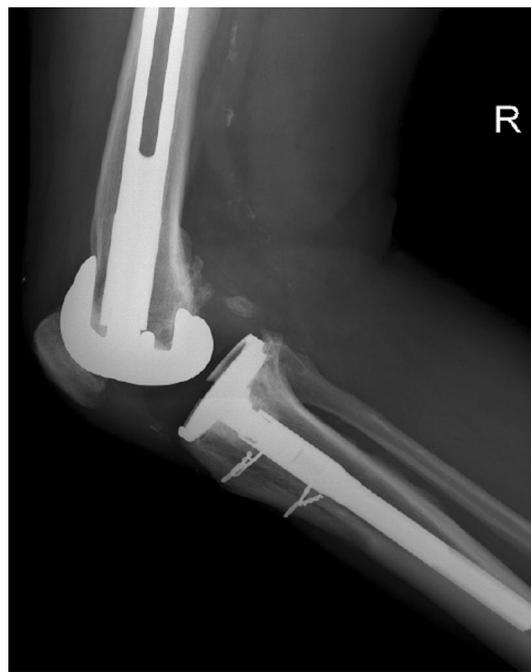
Knee lateral radiograph shows the consolidation of the anterior tibial tuberosity
